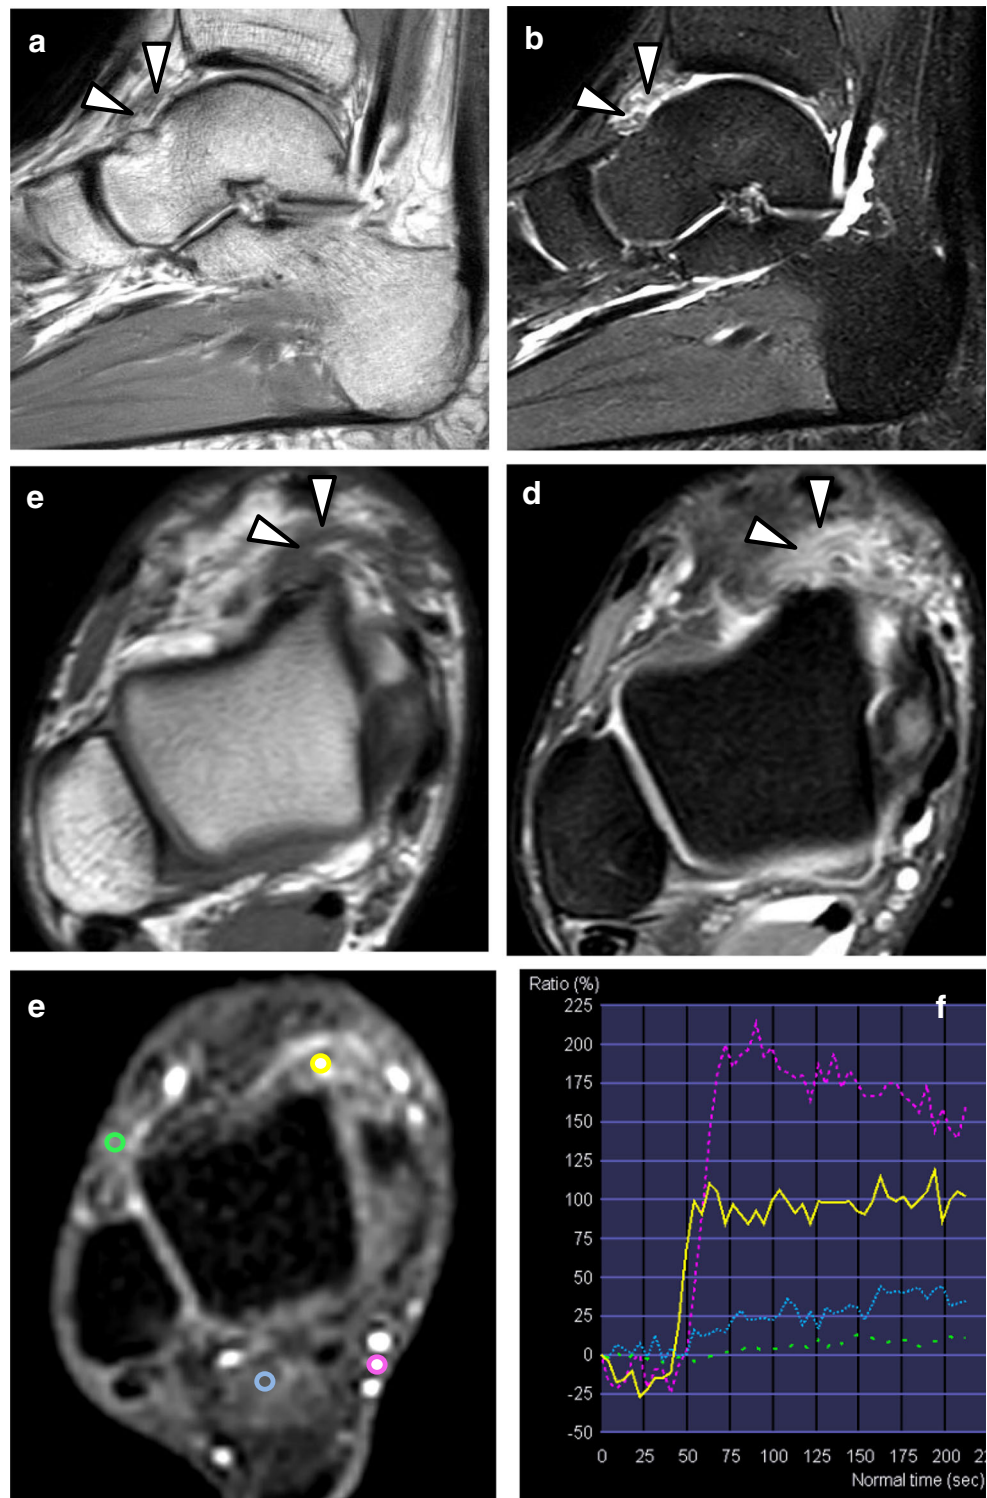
(a, b) Sagittal T1- (a) and fat-saturated T2-weighted (b) magnetic resonance (MR) images obtained at the time of recurrence, 6 years after the previous MR examination, show the disappearance of bone marrow edema within the talus, lack of visibility of the nidus, but persisting inflammatory tissue on the anterior aspect of the tibiotalar joint (arrowheads). (c, d) Transverse MRI sections show the same tissue (arrowheads). (e, f) Transverse dynamic sequence (e) and enhancement curves (f) obtained after intravenous injection of gadolinium show early and intense enhancement within the center of the lesion (nidus, the yellow region of interest (ROI) and curve), paralleling the enhancement observed within the tibial posterior artery (rose ROI and curve). Slower and limited enhancement is seen within muscles (blue and green ROIs and curves)
